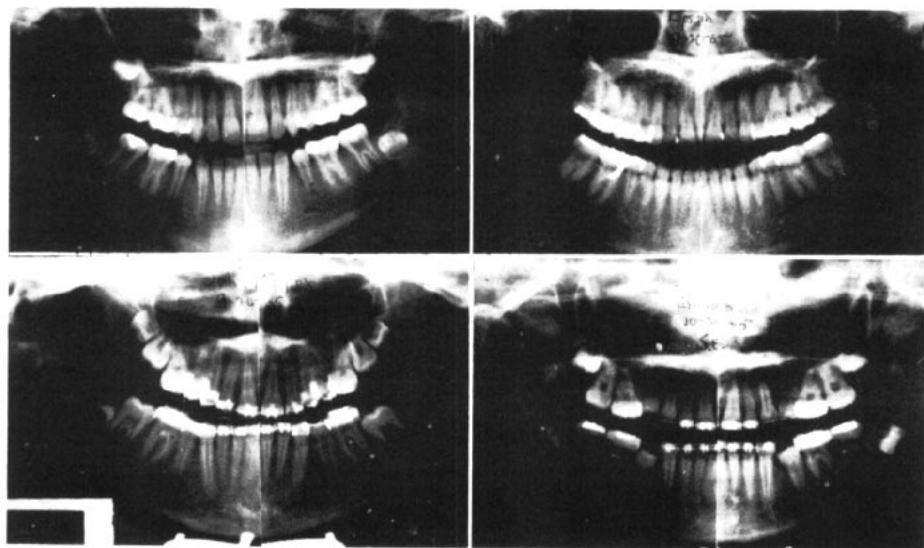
Serial extraction cases. Upper left, ready for a short period of mechanotherapy. Upper right, serial extraction upper arch only with removal of mandibular third molars prior to eruption. Lower views, progress panoramic radiographs during active treatment.
